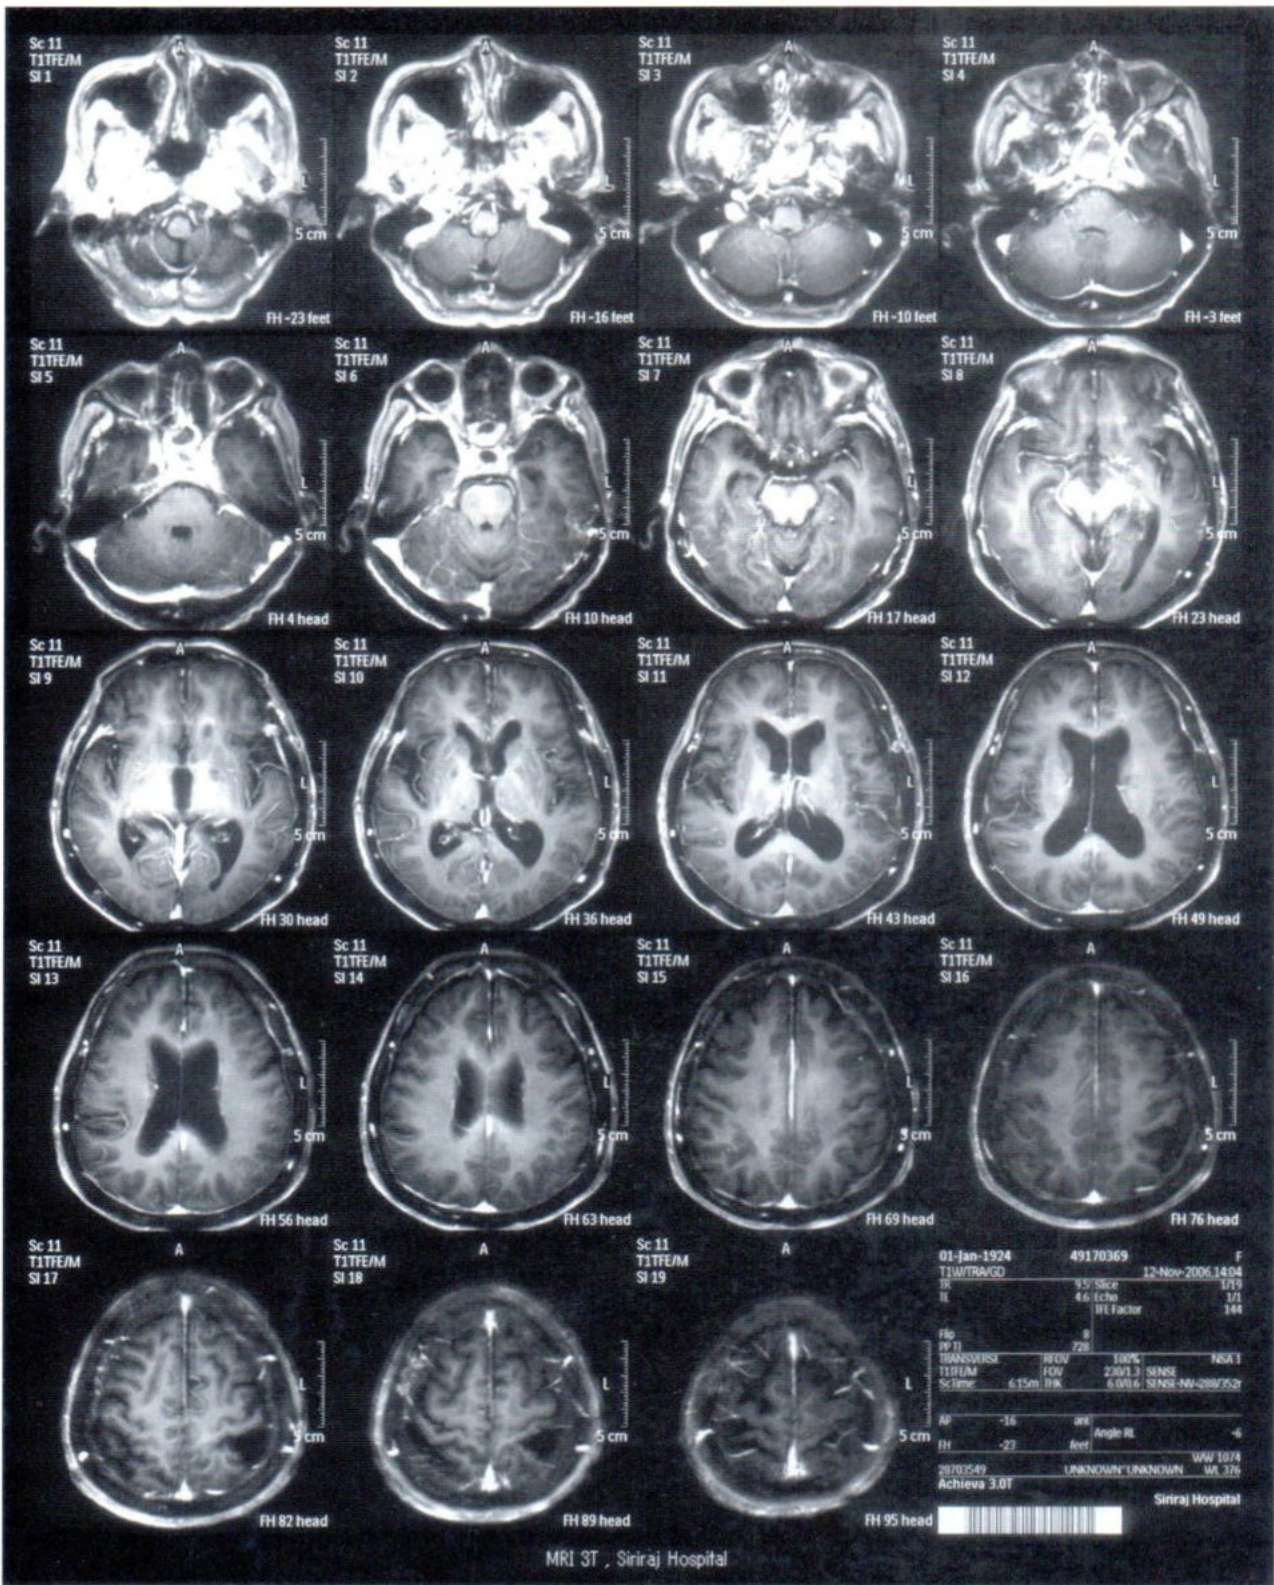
MRI brain shows generalized brain atrophy with secondary ventricular dilatation. No evidence of metastasis.
